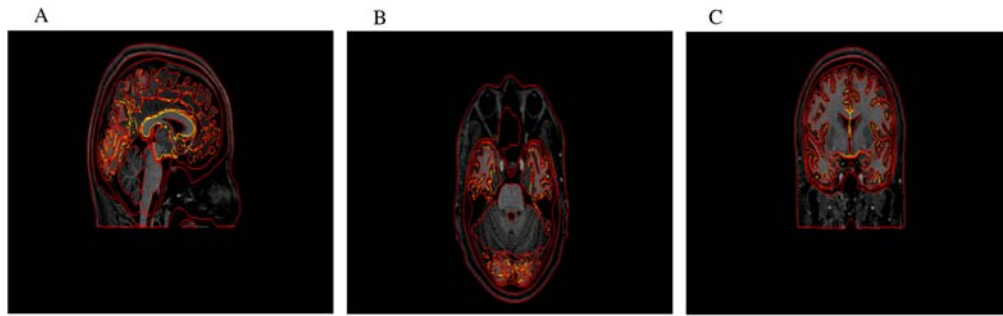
MRI tissue segmentation
